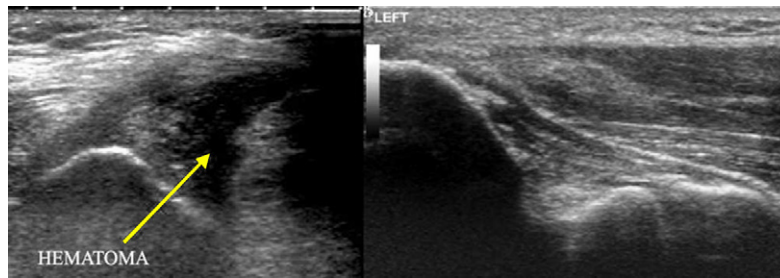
Right side, Ultrasound appearance at 48 hours following injury. There is a large medial haematoma (*yellow arrow*) and a full thickness tear of the common flexor tendon origin. No UCL was visualized in the expected anatomic position. Left side, For comparison, normal UCL appearance. This figure shows the relatively easy positioning of the needle for accurate PRP injection.
